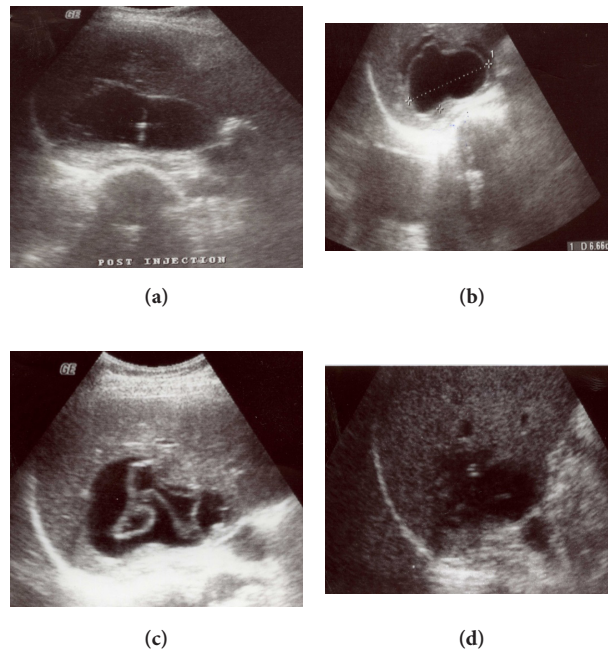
Another patient with simple hepatic hydatid cyst who treated with PAI, the sonographic follow up show: (a) Tip of needle seen within the cyst during injection of albendazole, (b) Immediately after injection with detached internal membrane. (c) Folded endocyst after 8 months. (d) Small cyst with irregular thick wall and inactive partially hyperechoic content at the final follow up sonographic pattern
